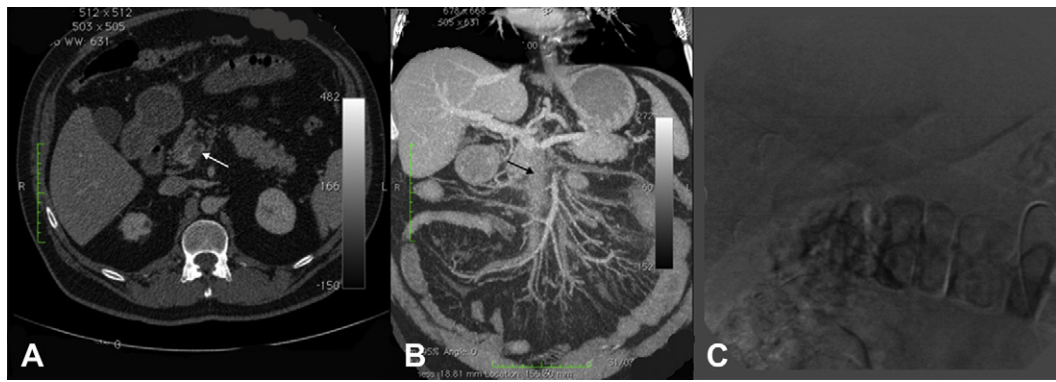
Images of the initial studies carried out before the treatment. (A) Computed tomography (CT) scan in the axial plane showing the presence of a thrombus in the proximal segment of the portal vein (*white arrow*). (B) CT scan with reformatting in the coronal plane and using the maximum intensity projection (MIP) function, which shows the presence of a thrombus inside the superior mesenteric vein (SMV, *black arrow*) and its branches, as
